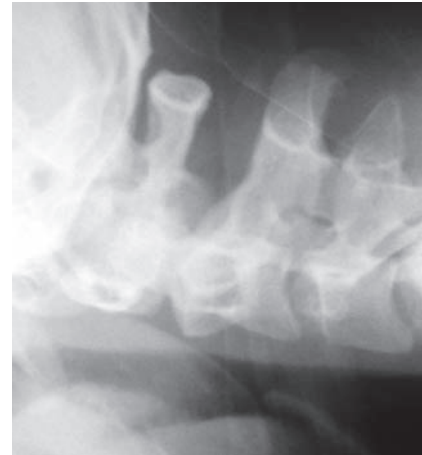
Plain x-ray lateral view of cervical spine showing normal vertebral bodies and soft tissue shadow
